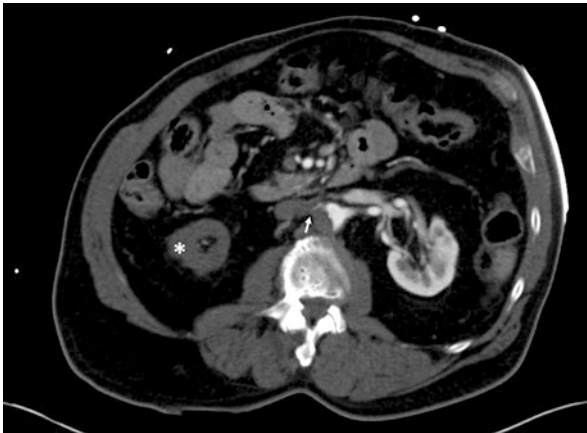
CT angiography of the abdomen demonstrating an aortic dissection with the left renal artery arising from the true lumen and an intimal flap extending to the ostium of the right renal artery, resulting in occlusion by the false lumen (arrow). Additionally there is hypoperfusion of the right kidney (asterisk), which is readily apparent, especially in comparison to the well-perfused left kidney
